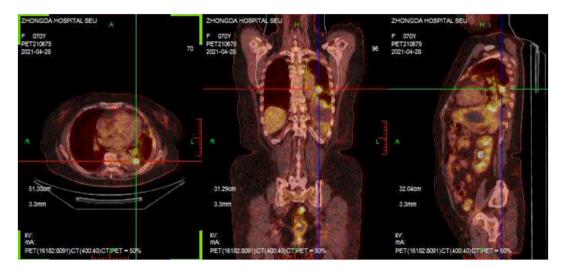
PET-CT images showed that there was a 1.9\*1.5cm nodule in the left lower lobe of the patient with an SUV value of 9.34.
